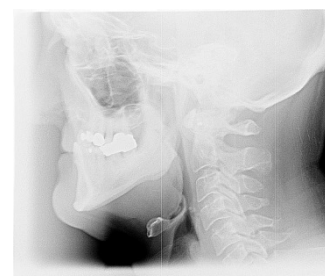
Radiographic image.
